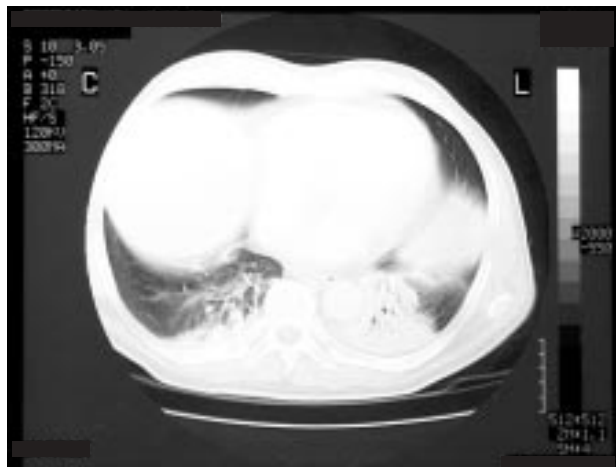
Chest CT scan. Bilateral pleural reaction with an area of condensed parenchyma with air bronchogram suggesting pneumonia of the left lung.
